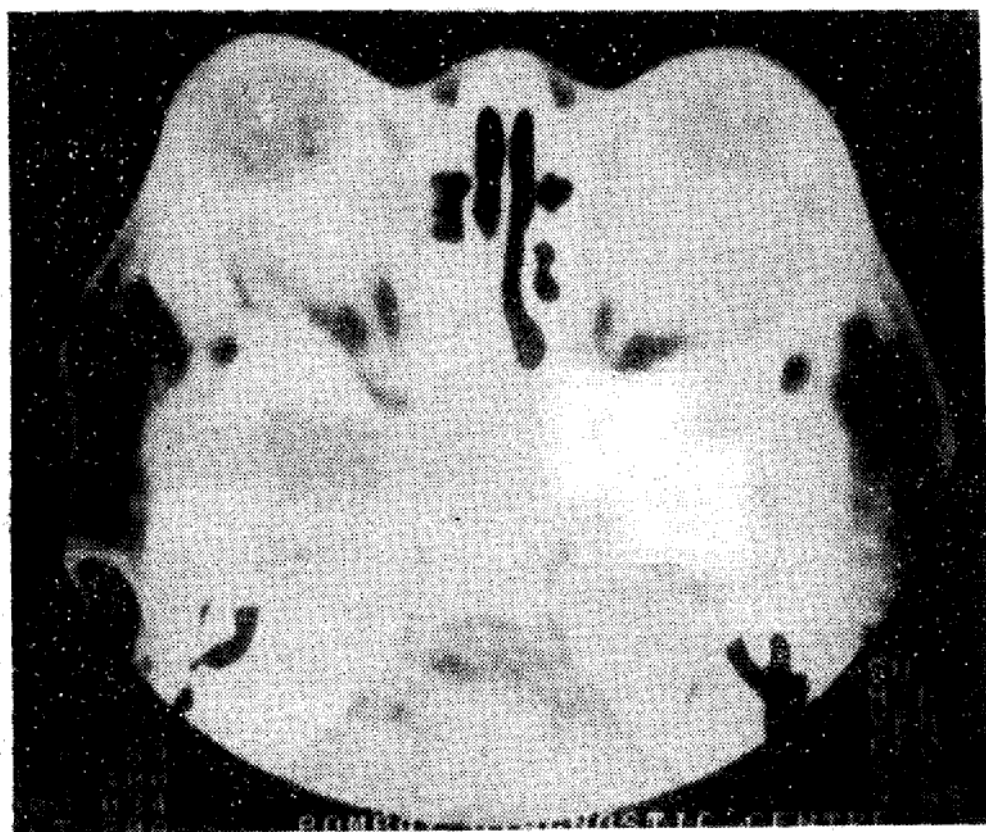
Computerised tomographic (CT) scan of the orbits showing bilateral retrobulbar masses.
